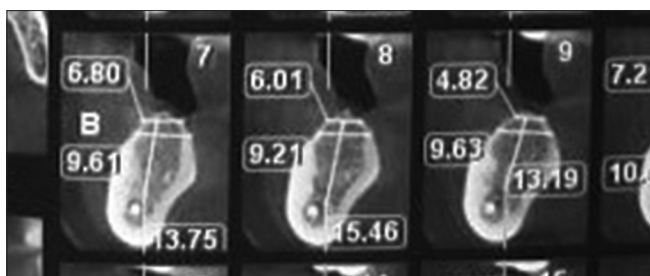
Cone beam computed tomography cross section of Case no 3 implant site 36
